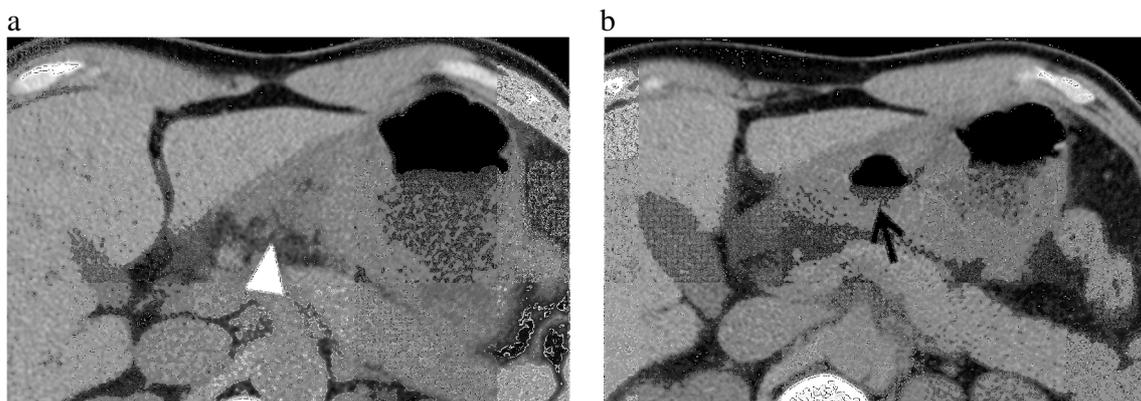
A 42 years old male patient who complaint acute abdominal pain revealed gastric ulcer by gastro-duodenal endoscopy. a) Increase of peri-gastric fat density (white arrowhead) was seen on unenhanced CT. b) Convex-shaped and low-density gastric wall thickening with large crater (arrow) was identified on the lower level of the same CT series.
